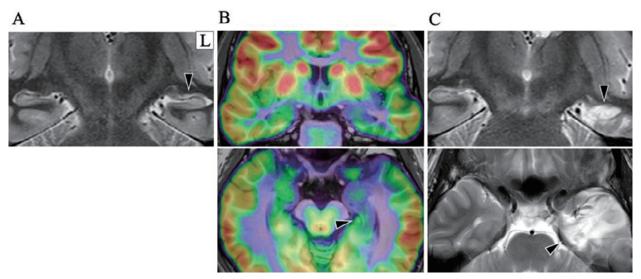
Preoperative and postoperative neuroimaging. A: Presurgical MRI showing no evidence of hippocampal atrophy. B: Presurgical FDG-PET fusion images showing reduced accumulation in the anterior basal portion of the left temporal lobe. C: Postsurgical MRI of hippocampectomy.
